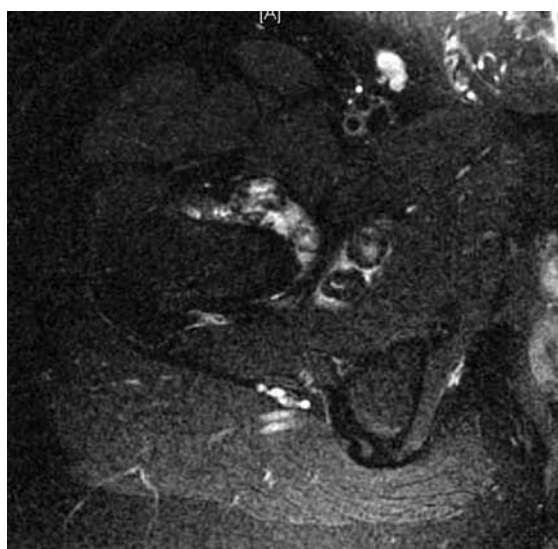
Axial fat saturated T2-W MR image of the right hip.
